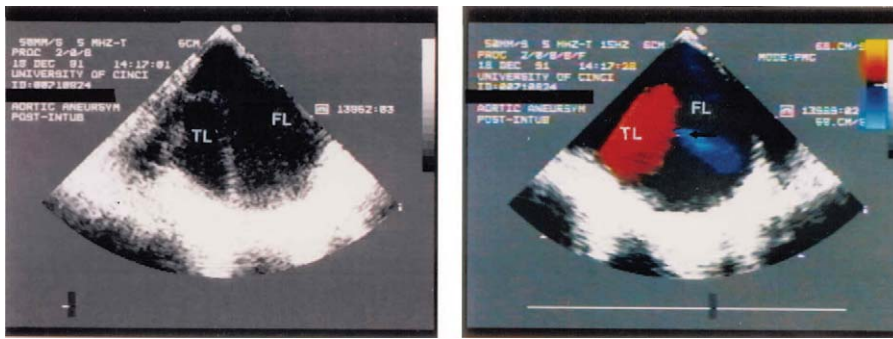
Left*, aortic dissection with intimal flap and entry site of distal thoracic aorta; *Right*, aortic dissection renal flow via color flow Doppler through intimal tear. TL, true lumen; FL, false lumen.
